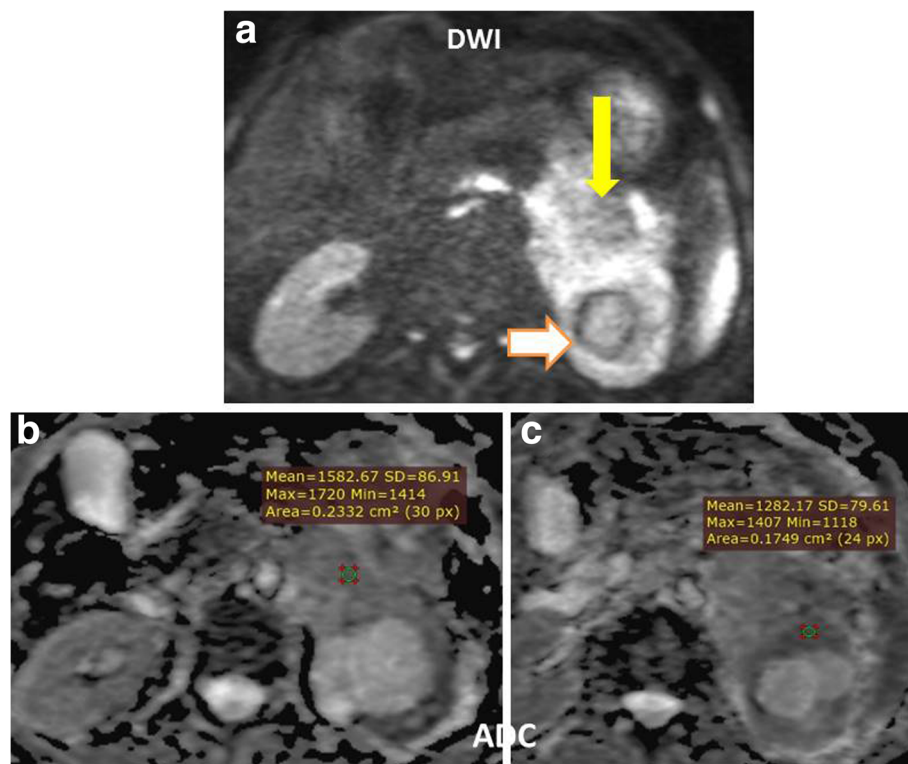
A 67-year-old male patient comes complaining from left hypochondrial pain and swelling. a–c DWI and ADC maps showed truly restricted pancreatic tail lesion extending extra-pancreatic and inseparable from the left kidney. The average ADC value from this lesion was $1.2\text{--}1.5 \times 10^{-3}$ mm^2/s (non-resectable lesion)
